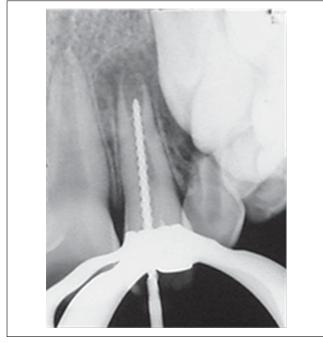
Periapical radiograph of root canal length determination with a size 80 K-file.
